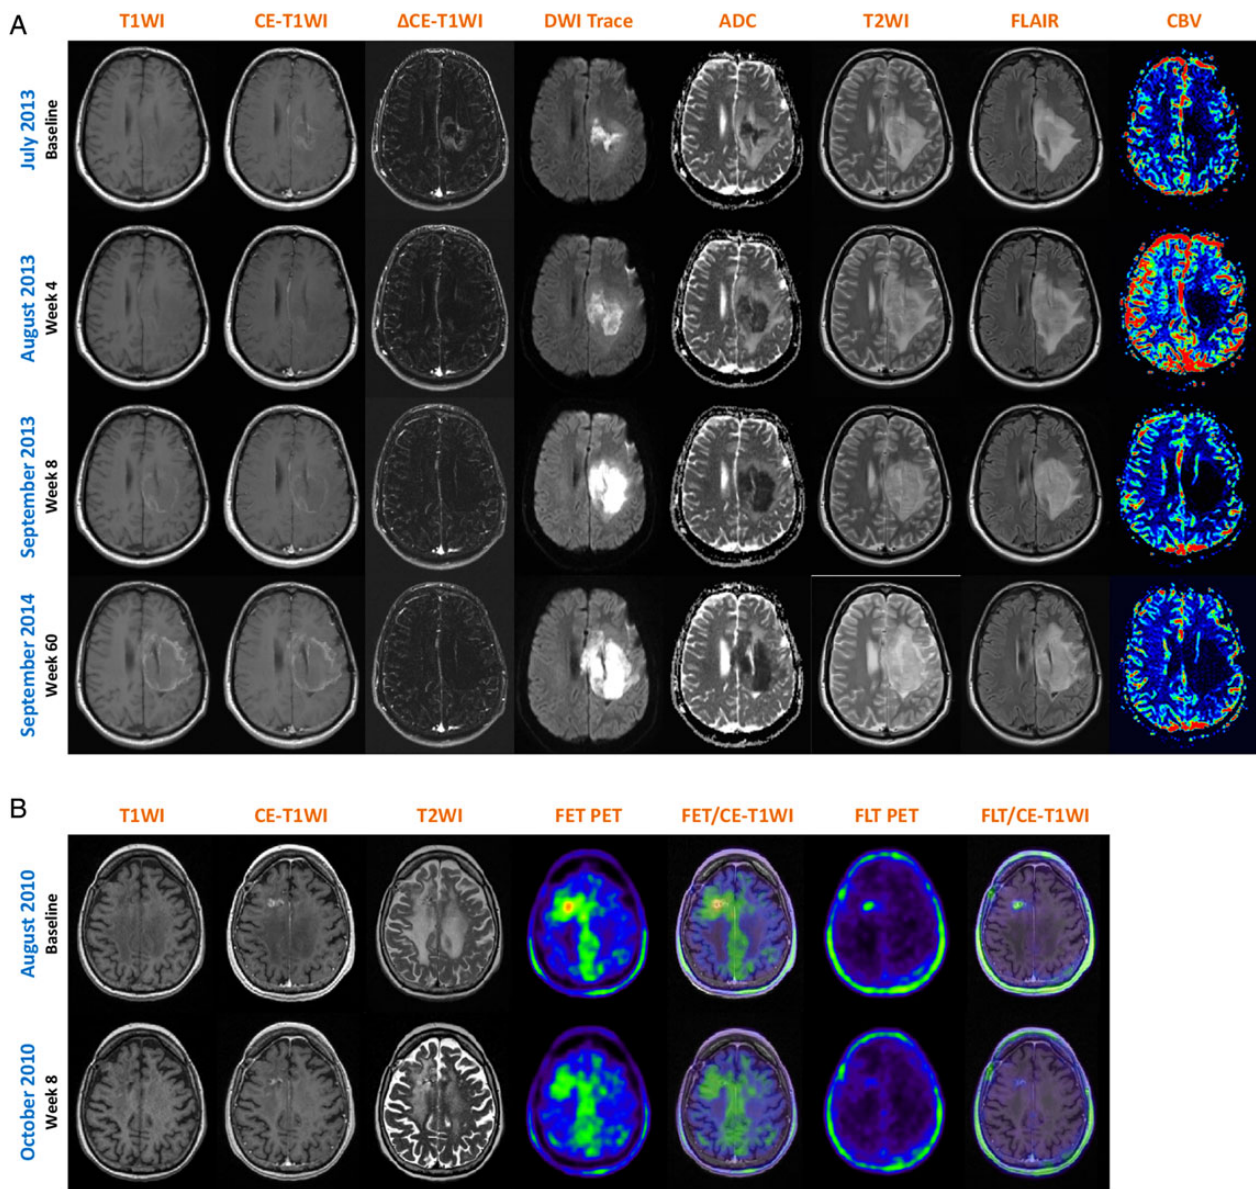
Representative patients with MRI and PET imaging during antiangiogenic treatment. (A) Baseline and follow-up MRI scans (wk 4, 8, 60) from a male patient with recurrent anaplastic astrocytoma who developed a long-lasting response under bevacizumab treatment (RANO criteria first follow-up scan after 4 wk: no contrast enhancement, significant reduction in T2/FLAIR signal abnormality). The patient developed early (wk 4) hyperintense tumor calcification on precontrast T1WI associated with an extended hypovascularized DWI restriction (low rCBV, high ADC values), indicating calcified coagulative tumor necrosis, blood vessel hyalinization, reactive astrocytosis/gliosis, and increased cellularity due to inflammatory cells. (B) Baseline and first follow-up MRI and ^{18}F -FET/ ^{18}F -FLT scans from a female patient with recurrent glioblastoma. According to RANO criteria, the patient presented with a partial response due to significant decrease of contrast enhancement and T2/FLAIR signal hyperintensity. At baseline, ^{18}F -FET PET revealed a focal high tracer uptake consistent with the contrast enhancement on MRI, but also a high ratio of nonenhancing metabolically active tumor. The follow-up scan showed a decrease of the focal tracer uptake; the BTV, however, remained stable (metabolic nonresponder). Importantly, ^{18}F -FLT PET demonstrated only tracer uptake dependent on elevated BBB permeability, thereby correlating with MRI contrast enhancement at baseline and the follow-up scan. $\Delta\text{CE-T1WI}$ = delta T1 map presenting the real contrast enhancement; T2WI = T2-weighted imaging; CBV = relative cerebral blood volume (DSC PWI); FET = ^{18}F -FET PET; FET/CE-T1WI = image fusion of ^{18}F -FET PET and CE-T1WI; FLT = ^{18}F -FLT PET; FLT/CE-T1WI = image fusion of ^{18}F -FLT PET and CE-T1WI.
